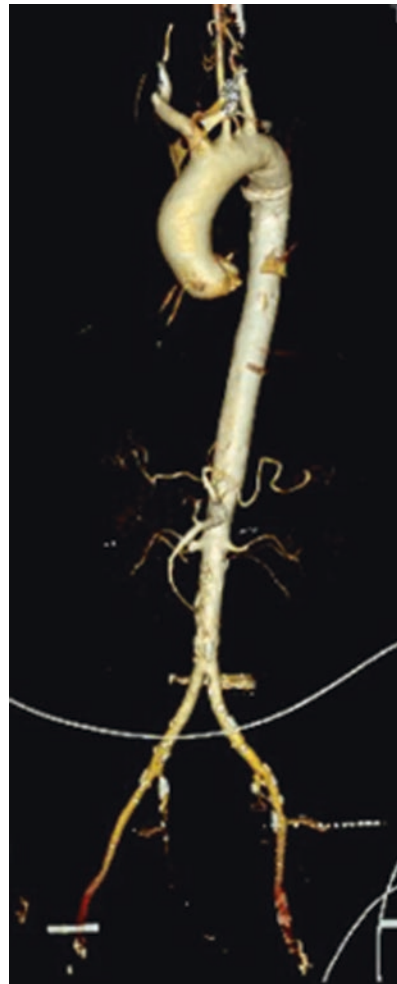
Multidetector CT (MDCT) angiography three-dimensional volume-rendered (3D-VR) image allows scan of whole body
